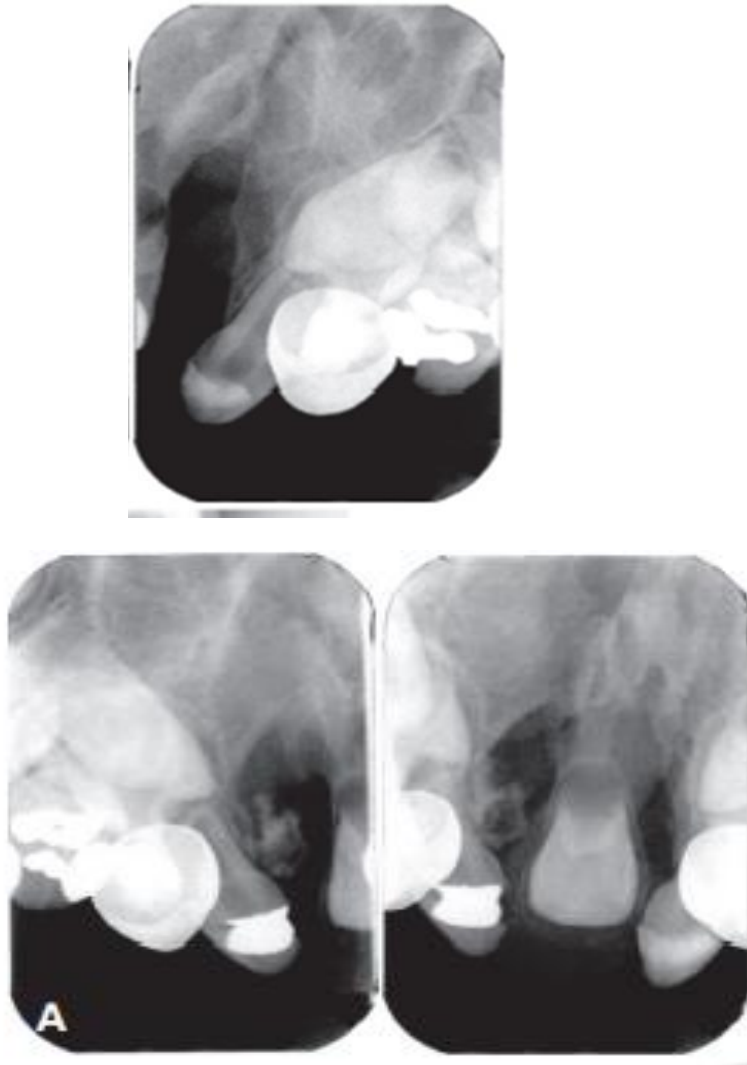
Intraoral radiographic (A) Bilateral clefts of the maxilla in the lateral incisor regions and defects of the dentition. (White and Pharoah,2014).
